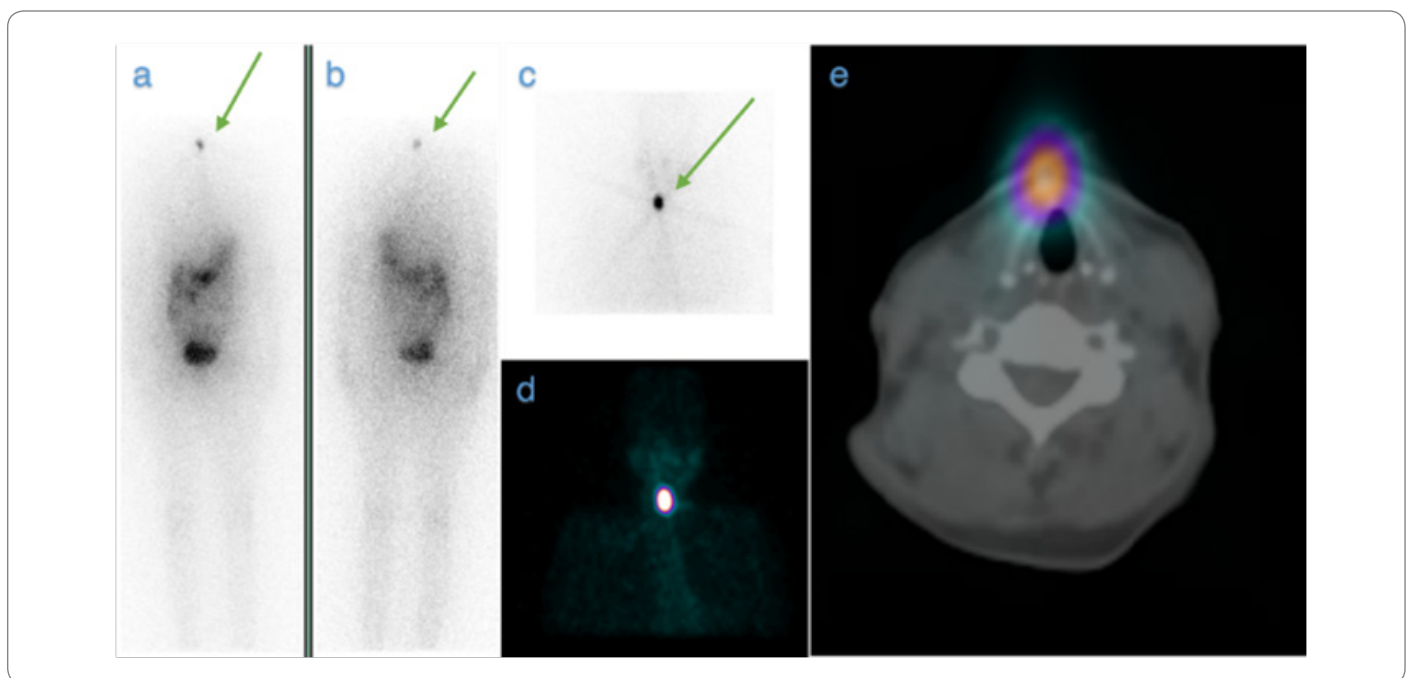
1st ^{131}I whole body scan of patient; planar images revealed physiological tracer uptake in stomach, intestine with focal ^{131}I uptake at level of neck in anterior. (a) and posterior. (b) view. High count spot anterior view revealed uptake in neck. (c) SPECT MIP image confirmed ^{131}I uptake in thyroid bed which is further confirmed by Fused SPECT/CT images to be a remnant thyroid bed uptake (e).
